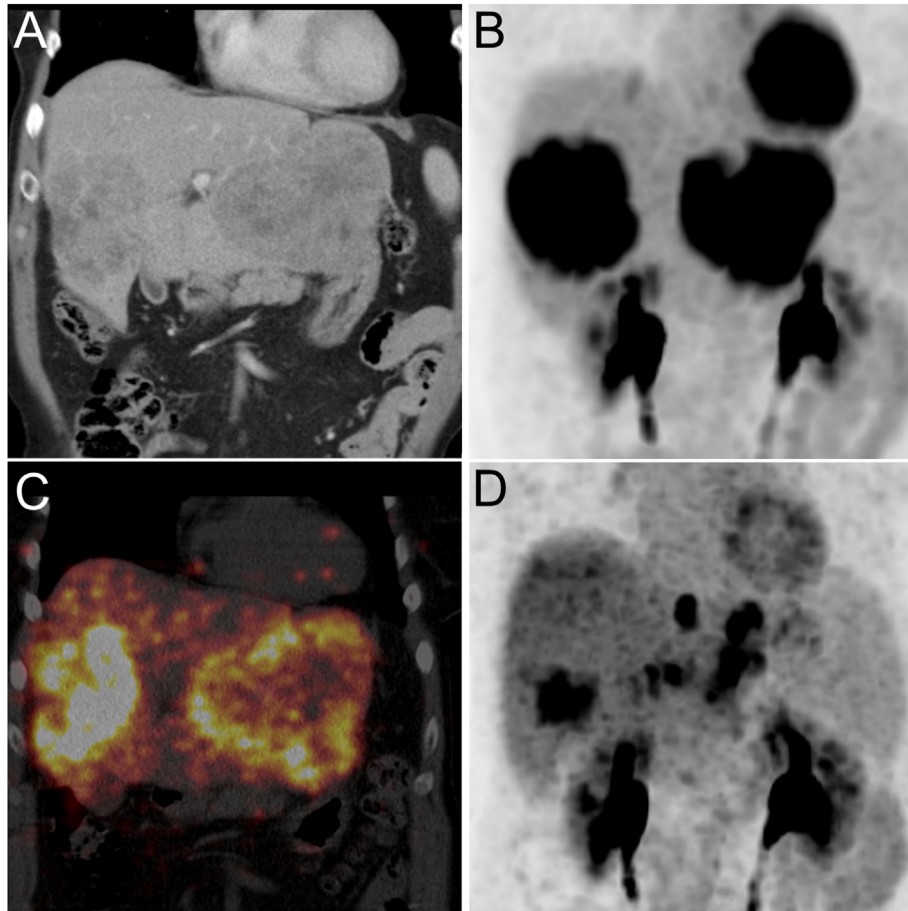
Example of a glass yttrium-90 (^{90}Y) radioembolisation of metastatic colorectal carcinoma in salvage setting. (A, B) Baseline portal-phase computed tomography scan and ^{18}F FDG-positron emission tomography (^{18}F FDG-PET) of a patient with two large metastases in the left and right liver lobes (10.3 and 9.2 cm). (C) Post-treatment ^{90}Y -PET showing favourable tumour targeting, post-treatment dosimetry revealed a tumour absorbed dose of 114 Gy to the lesion in the left lobe and 197 Gy to the lesion in the right lobe. (D) Three-month follow-up ^{18}F FDG-PET showing partial response of the two treated lesions, as well as three small new hepatic lesions in the left lobe.
